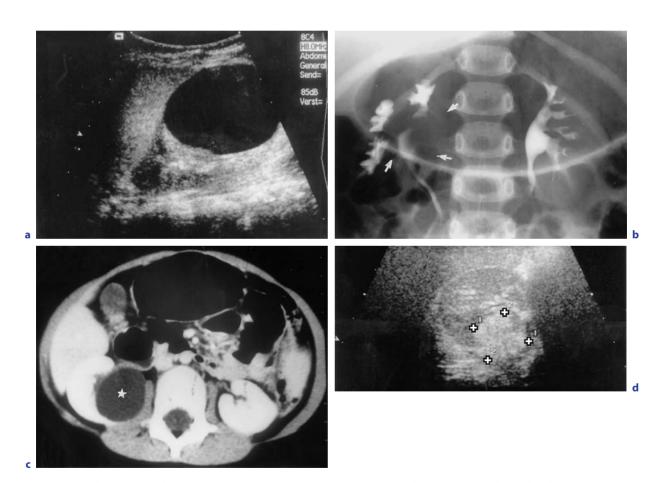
d. Simple renal cyst: a A radiologically simple, but big renal cyst of the lower pole of the left kidney on US with compression of parenchyma, in a longitudinal section, in a 4-year-old boy. b IVU of a central cyst of the right kidney demonstrates distortion and elongation the calyces by the cyst seen as an area of increased radiolucency (arrows). c Corresponding CT demonstrates the simple cyst (asterisk) with compression of the renal hilus/hilar structures in an 8-year-old girl who was consecutively operated on. d US of the postoperative situation with echogenic (= fatty) tissue in the former cyst (+ +) on a transverse section
